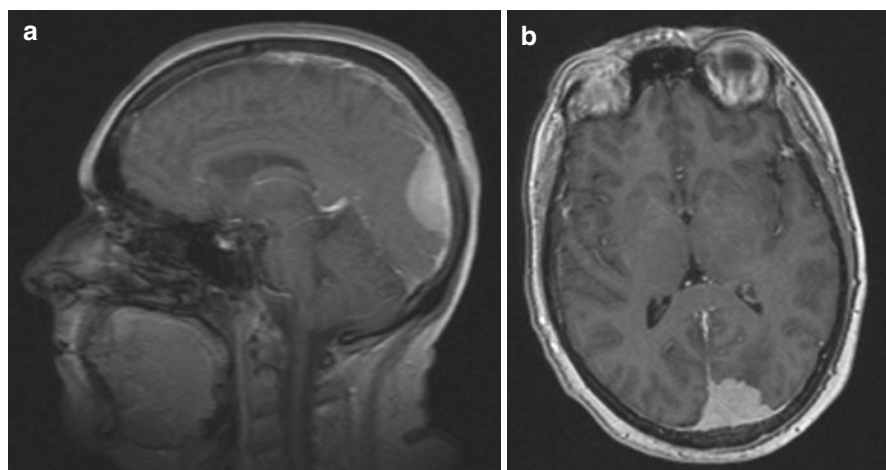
T1 weighted axial MRI showing an enhancing mass lesion indenting the occipital pole on the left side
